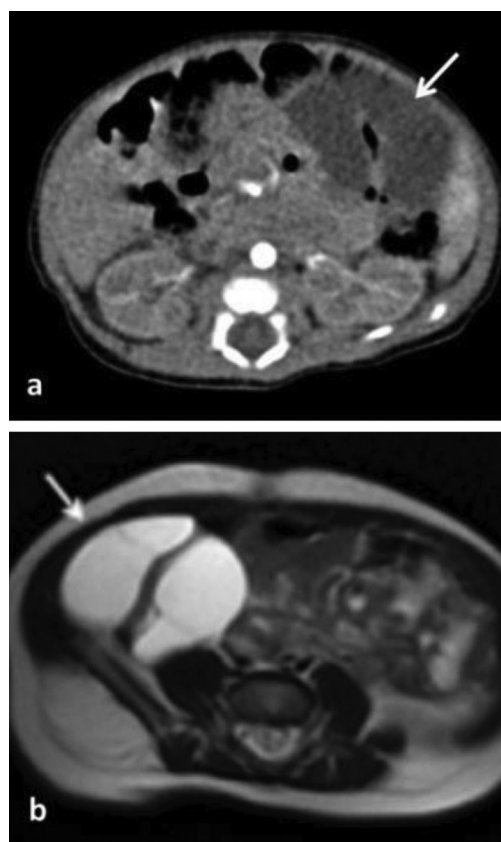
a) Axial computed tomography scan shows a well-defined, hypodense lesion on the left side (arrow) which surrounds the intestinal segment. b) Axial T2-weighted imaging shows migrated-cystic lesion from the left side to the right side (arrow). Note that internal septations and surrounded-intestinal segment are also seen
